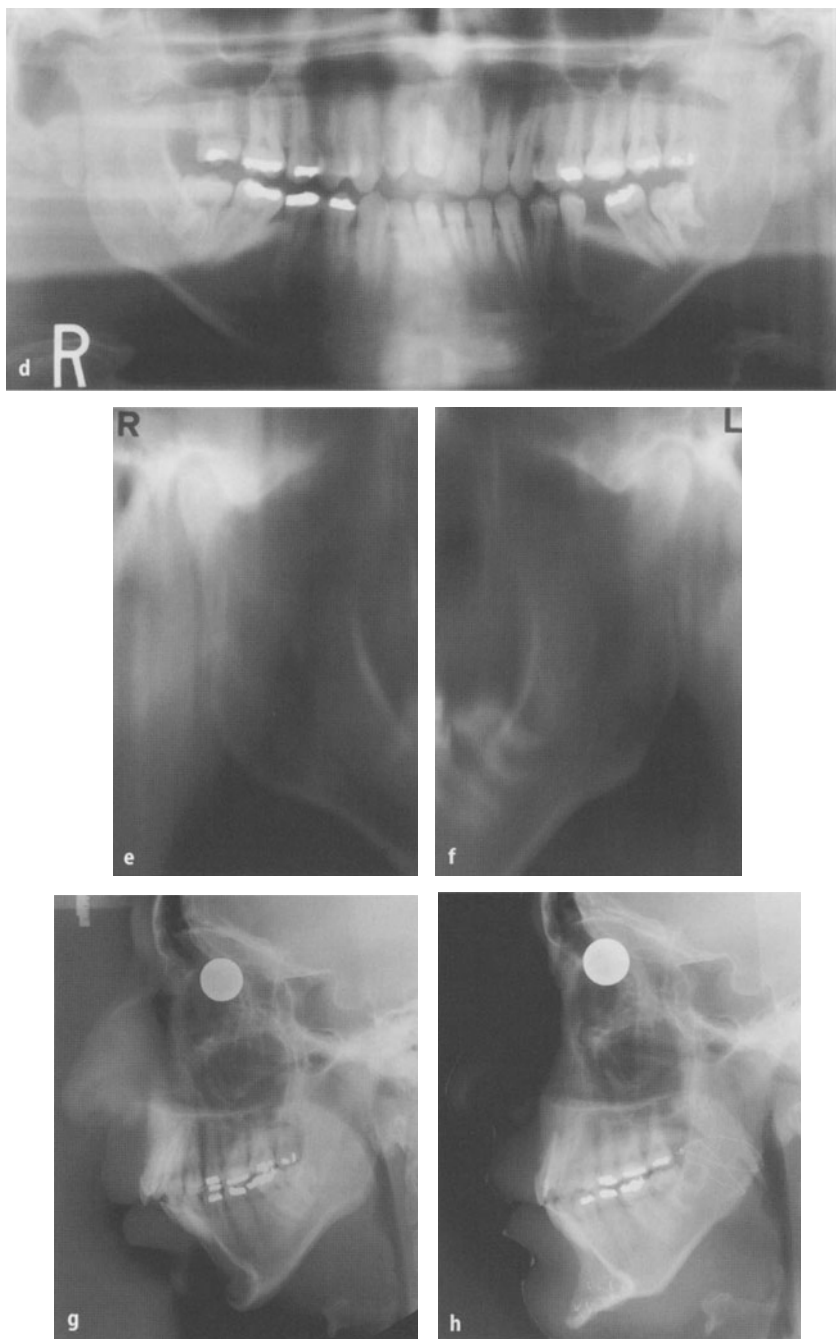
Case of anlage-induced bilateral hemimandibular hypoplasia with normal condyles, producing symmetrical micromandibulism with severe retro- and hypogonia. d Preoperative panoramic radiograph, e right and f left TMJ tomograms including the rami do not show any real abnormality of the condyles. g The lateral cephalogram shows the skeletal background to the patient's appearance. h The lateral cephalogram taken 1 year after surgery shows that normal skeletal contouring has been achieved. Note the mass of bone apposition above the two slices of chin advancement
